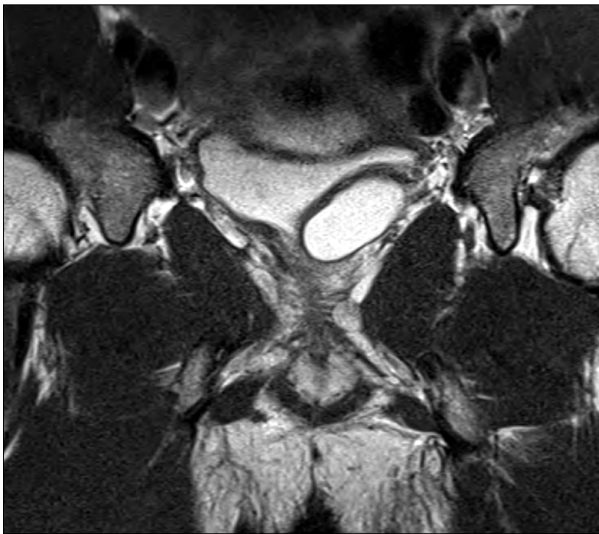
Coronal view of pelvis MRI showing a left seminal vesicle cyst.
